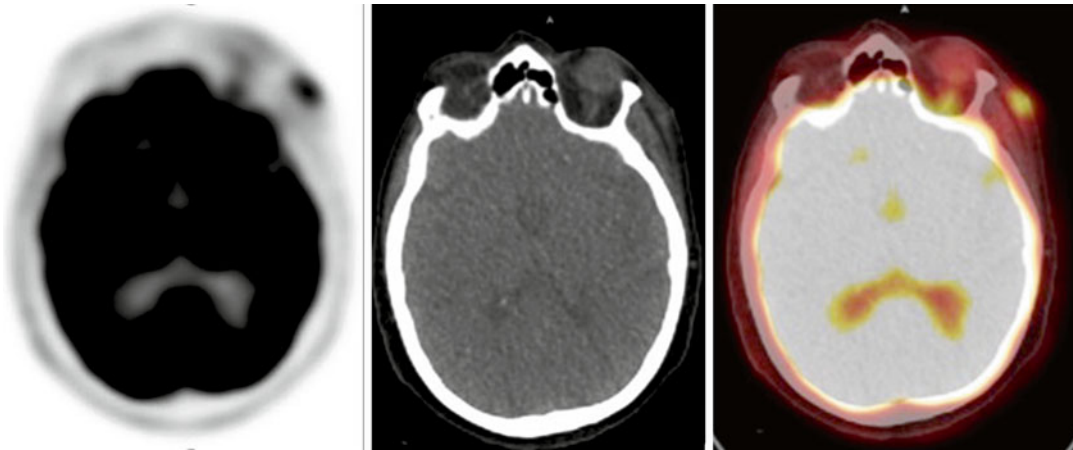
Example of the pattern of [^{18}F]FDG uptake in a patient with vasculitis showing involvement of the left temporal artery
